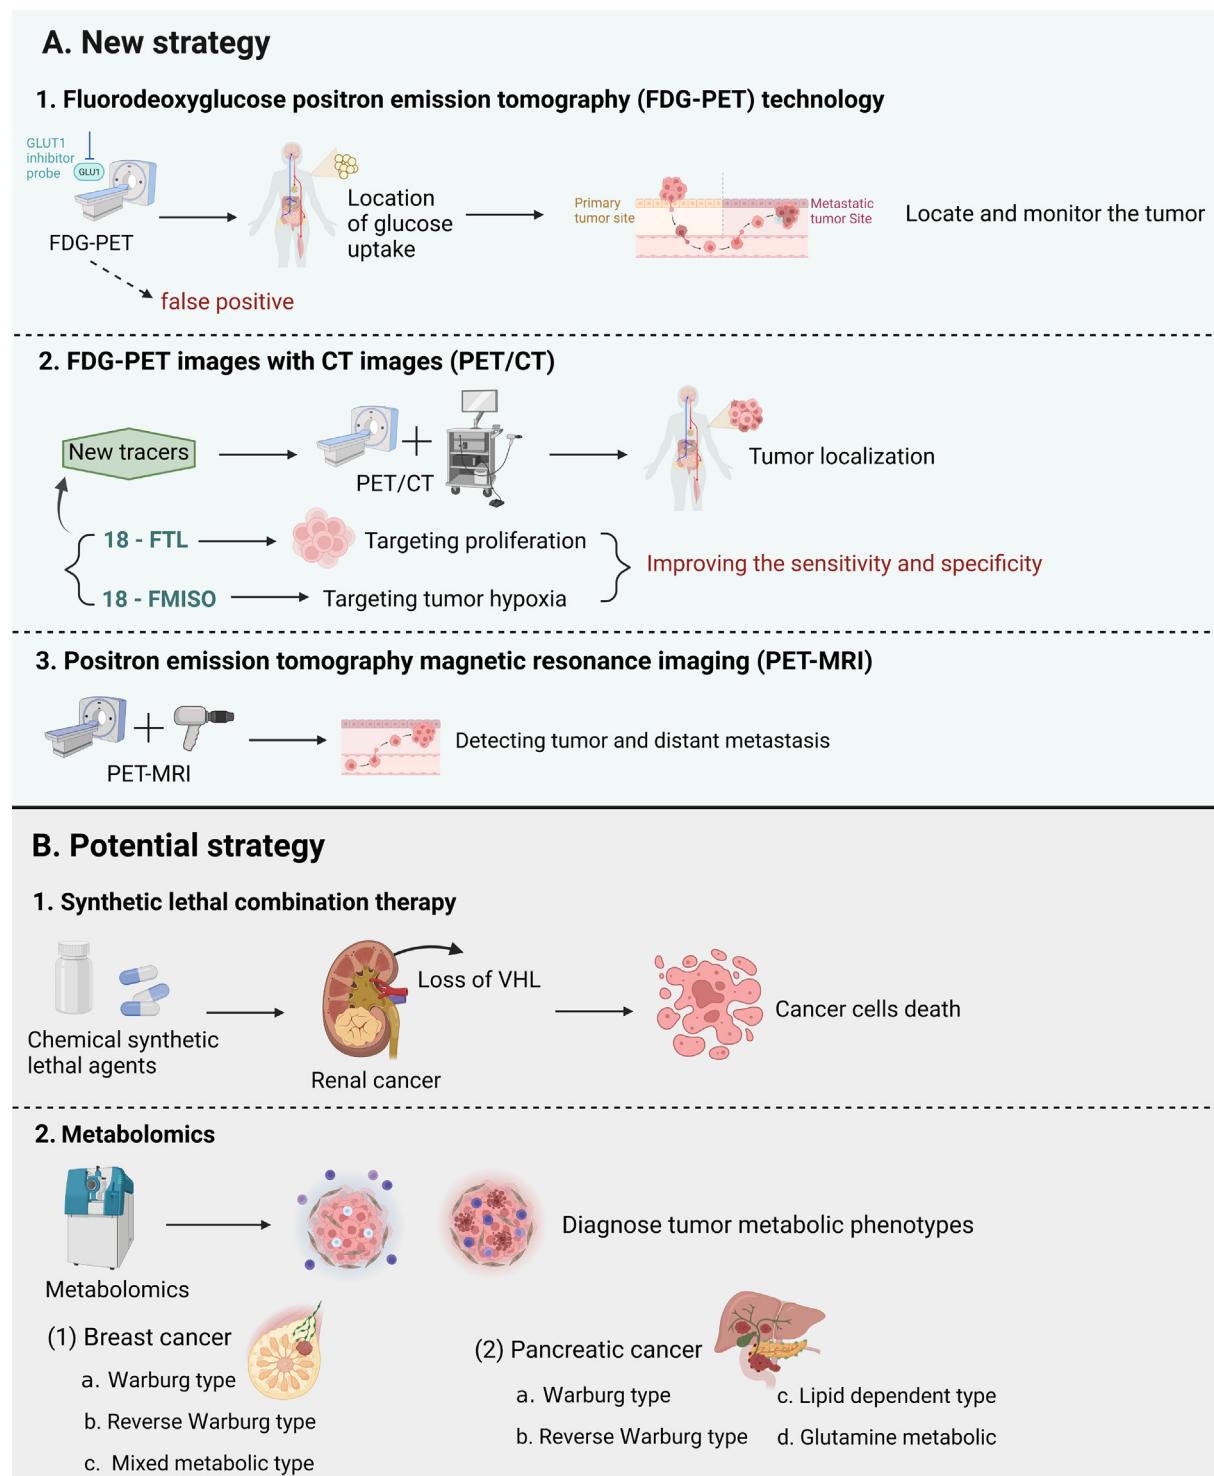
New and potential strategies for cancer treatment targeting the Warburg effect. (A) New strategies include fluorodeoxyglucose positron emission tomography (FDG-PET) technology, FDG-PET images with CT images (PET/CT) technology, and positron emission tomography magnetic resonance imaging (PET-MRI) technology. (B) Potential strategies involve synthetic lethal combination therapy and metabolomics which is used for tumor typing.
